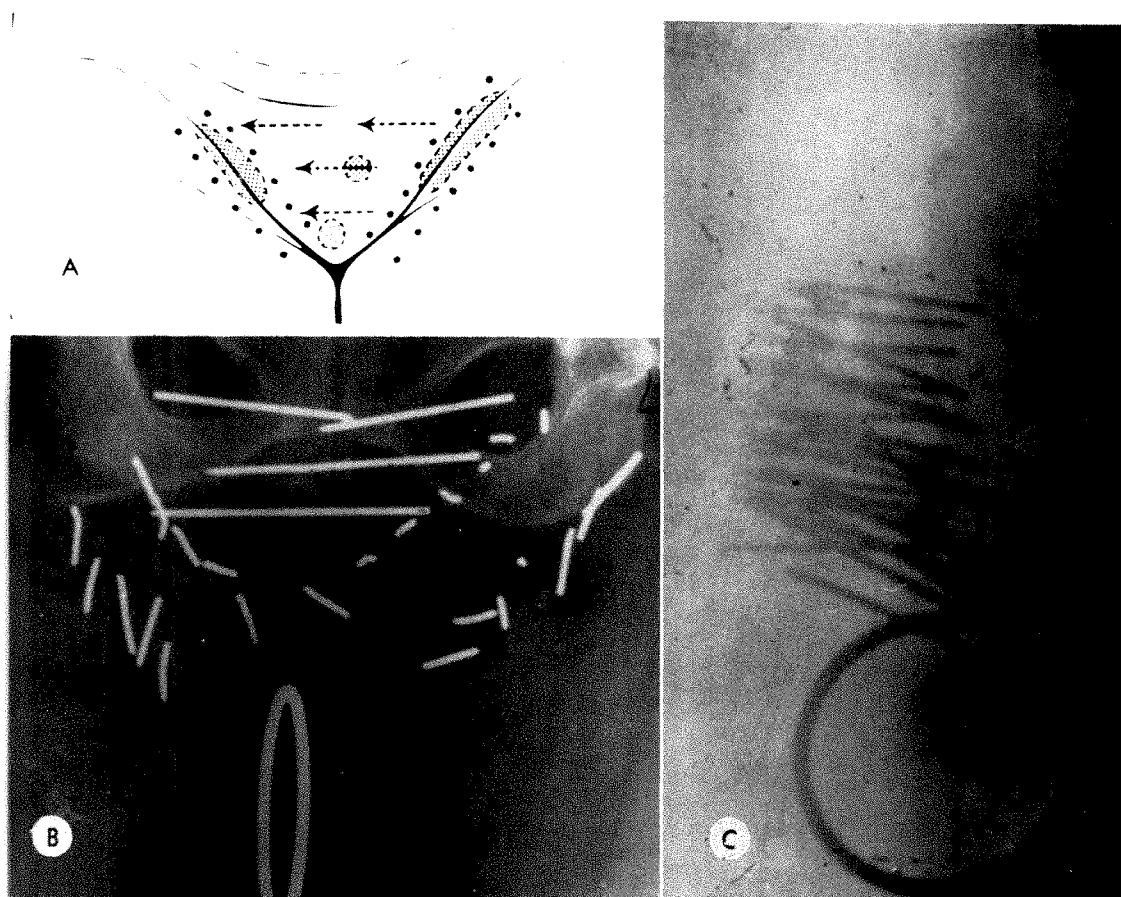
M.W. 50 N F. *Recurrent cutaneous and subcutaneous tumor after total vulvectomy and bilateral groin dissection. Combined 220 kv. of roentgen therapy and interstitial radium was indicated.*
